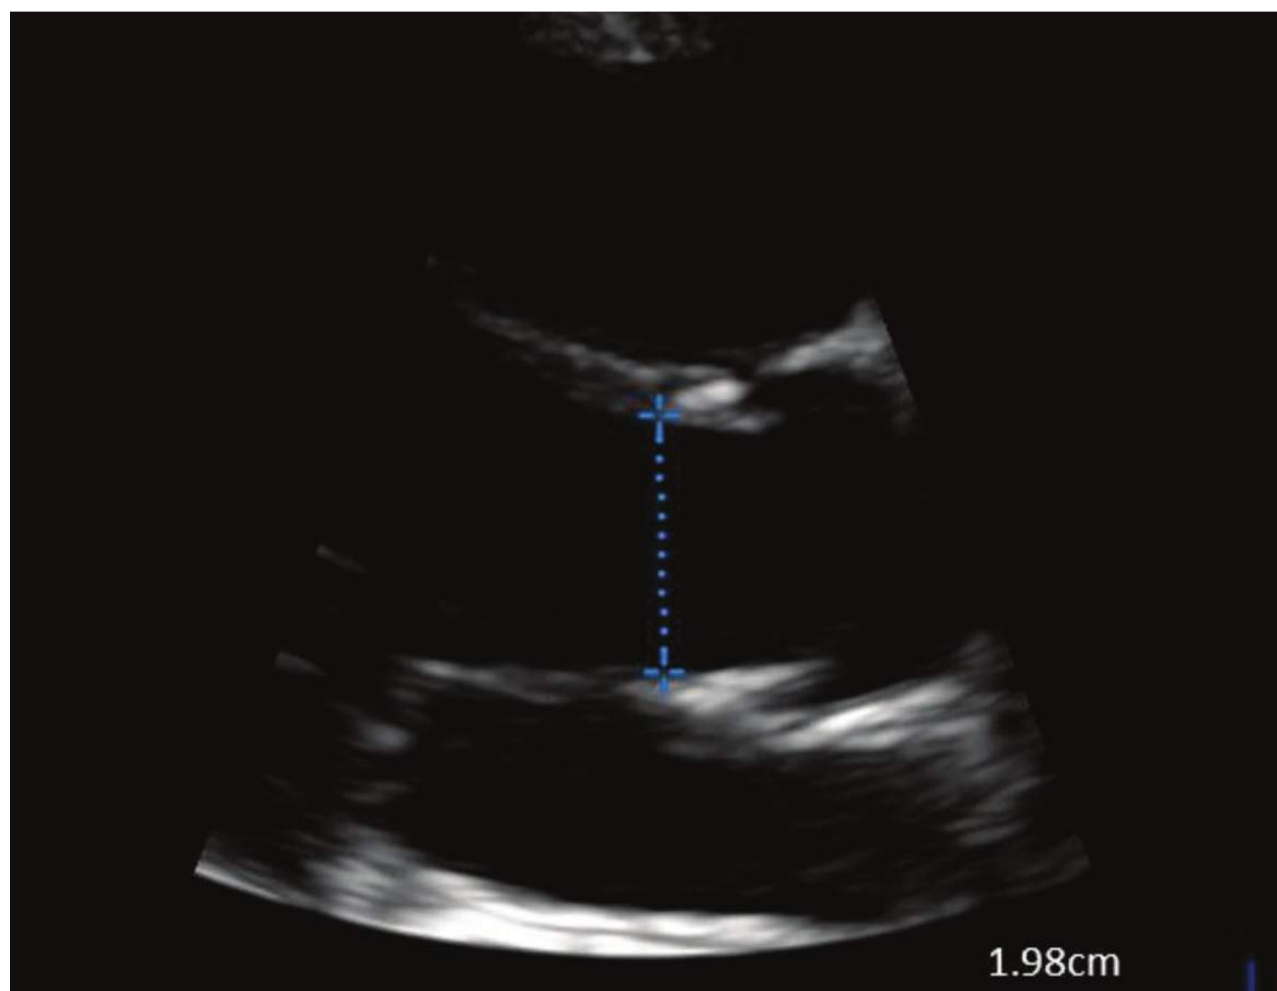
Measurement of LVOT diameter at aortic valve cusps. This is a parasternal long-axis view on zoom mode with calipers measuring the LVOT diameter at 1.98 cm. This view is obtained by placing the probe at the fourth intercostal space lateral to the left sternum. (Reproduced with permission from Dinh VA, Ko HS, Rao R, Bansal RC, et al: Measuring cardiac index with a focused cardiac examination in the ED, *Am J Emerg Med*. 2012 Nov;30(9):1845–1851.)
